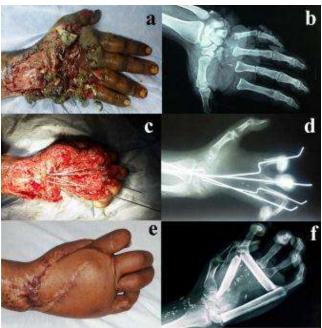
Free fibular osteocutaneous flap for large-sized dorsal bone and soft tissue defect of the right hand of 24 years male patient; a & b: preoperative clinical and x-ray photos, c & d: postoperative after debridement (1st stage)
